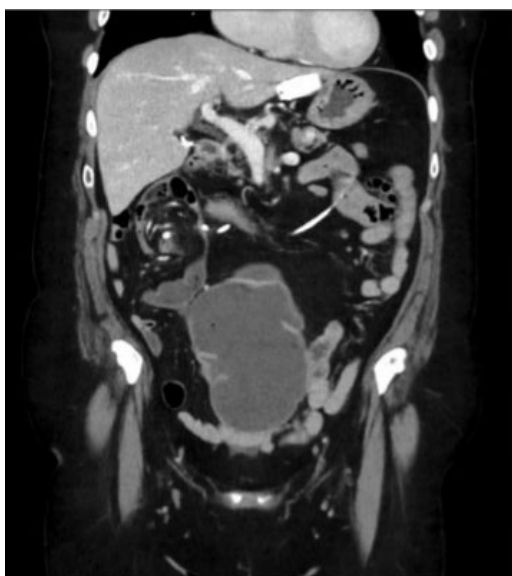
Computed tomography—Coronal image: Cecal volvulus with evident transition point and swirling of the mesentery anterior to the right kidney.
